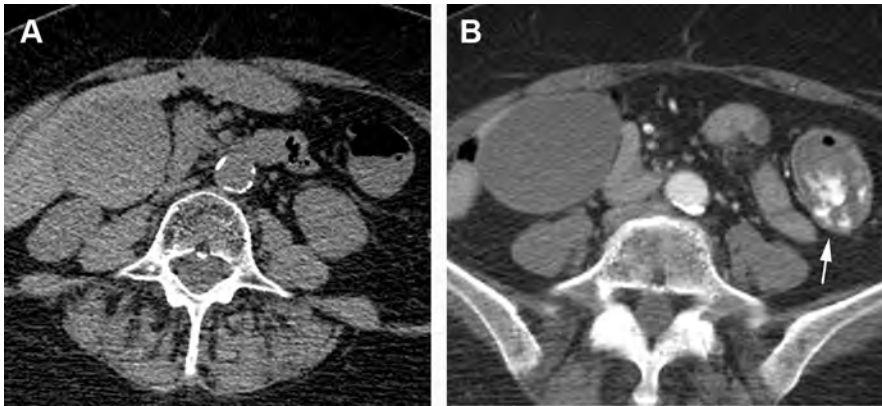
CTA of active GI bleed. A 76-year-old woman with history of diverticulosis and recurrent lower GI bleeds presents with hematochezia. Axial precontrast (A) and arterial phase (B) images from a CTA examination demonstrate contrast extravasation into bowel lumen in the descending colon (*white arrow*), consistent with active GI bleeding. Precontrast images are critical to ensure that contrast extravasation is not confused for hyperdense enteric contents. Subsequent colonoscopy revealed a diverticular bleed.
